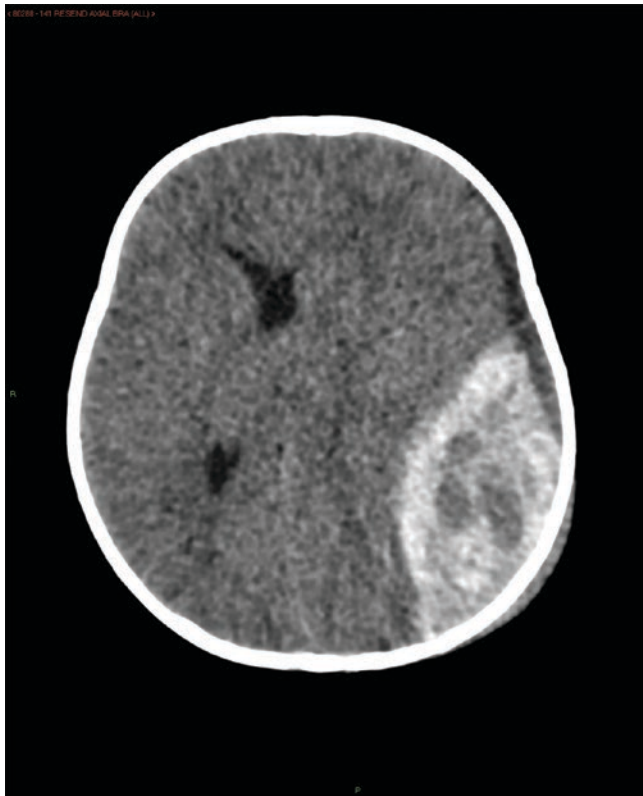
Large extradural haematoma. Axial CT image shows a large, left-sided extradural haematoma, limited posteriorly by the left lambdoid suture. There is significant mass effect on the left cerebral hemisphere and left-to-right midline shift
